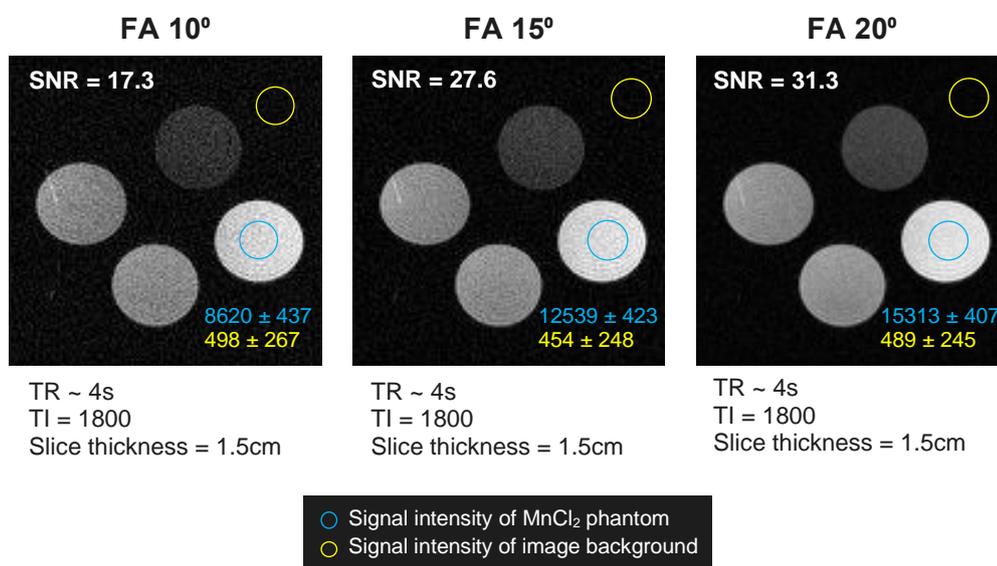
Representative T1-weighted image acquired at different FA.
